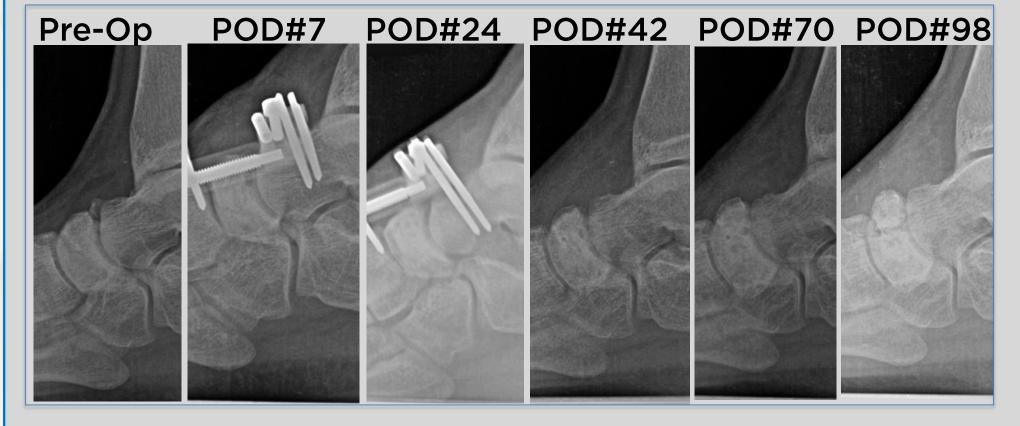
Radiographic Progression of Sclerosis
